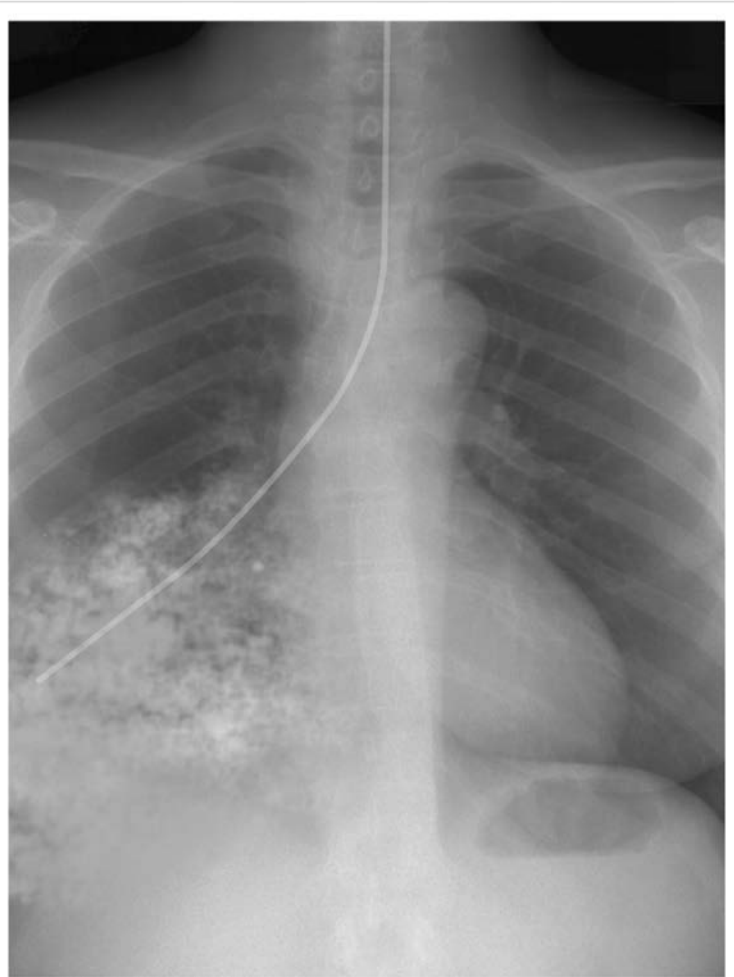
Chest Radiograph Representing
